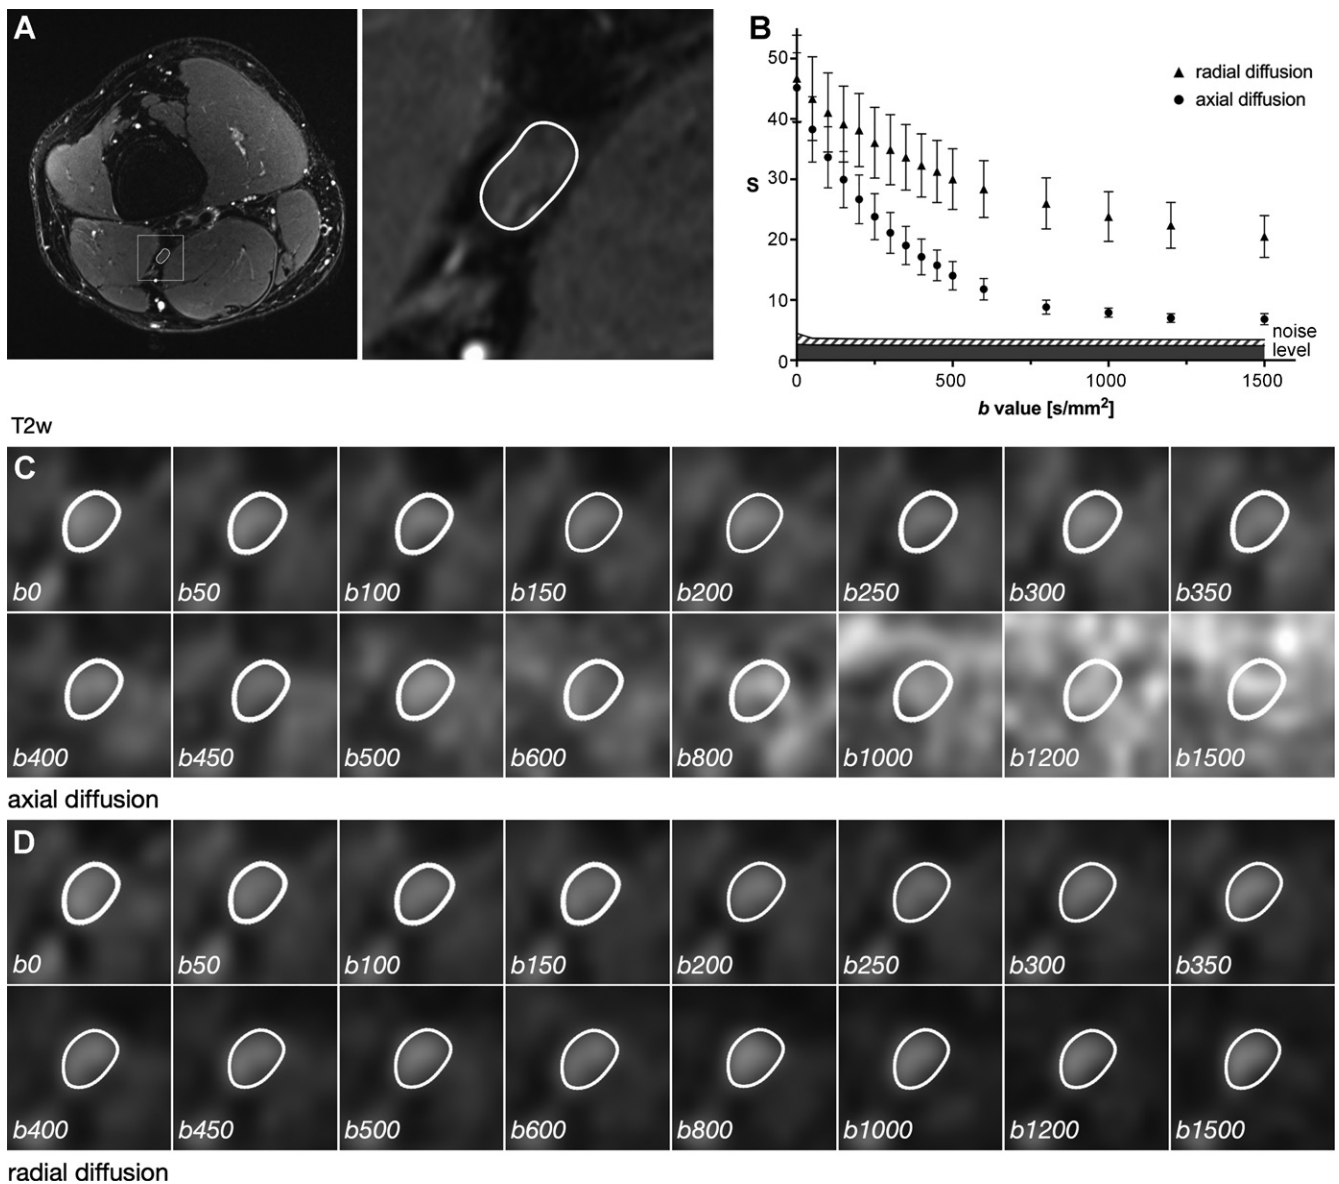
Diffusion-weighted imaging signal decay in healthy volunteers. (A) T2-weighted (T2w) images and series of diffusion-weighted images at 16 measured b values in (C) axial and (D) radial directions in a representative healthy volunteer. Segmentation of the tibial nerve is indicated by a white contour. (B) Inserted graph depicts the diffusion-weighted signal (S) measured within the region of interest (ROI) of the nerve as a function of b in healthy volunteers (arbitrary units). Error bars represent 95% CIs. Noise levels within a standardized region of interest are also shown with 95% CIs (light and dark gray shaded areas). Signal in ROI of the nerve remains well above noise level. In C and D, the window level of each magnified image is set to a linear gray scale from 0 to twice the magnitude signal of each ROI of the nerve.
